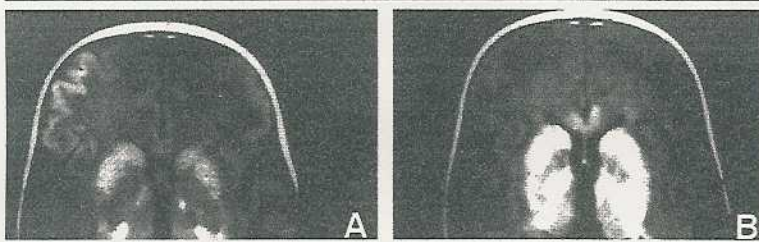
Representative axial T1-weighted MRI images of L.K. at baseline (A) and at 12 months after gene transfer (B).
